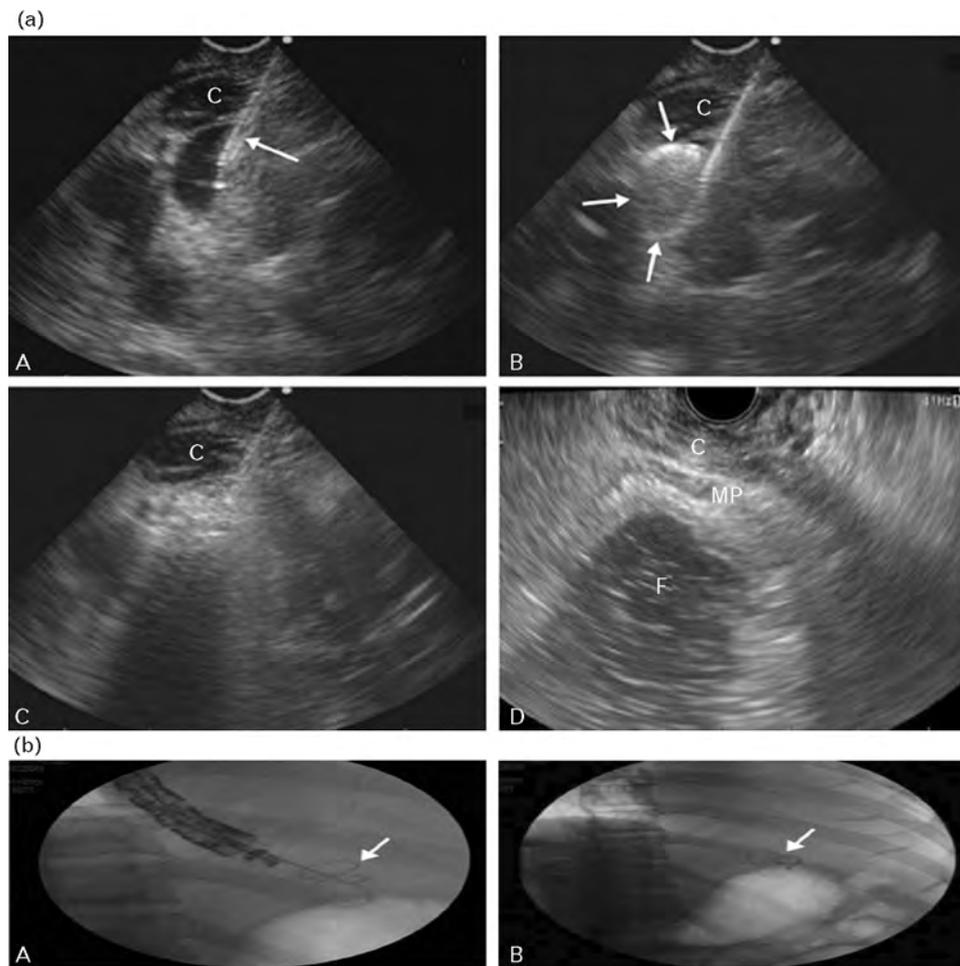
(a) Transesophageal EUS showing fundal varix targeted with a 19-gauge needle (arrow) (A); deployment of coil (arrows) through the 19-gauge needle (B); injection of 1 ml of cyanoacrylate glue through the 19-gauge needle to obliterate the varix lumen (C); eradication of fundal varices (D). (b) Fluoroscopic view showing A, coil (arrow) insertion into a gastric varix and B, appearance after intravariceal deployment. C, crus muscle; F, fundus; MP, muscularis propria of stomach wall. Data from [15].
